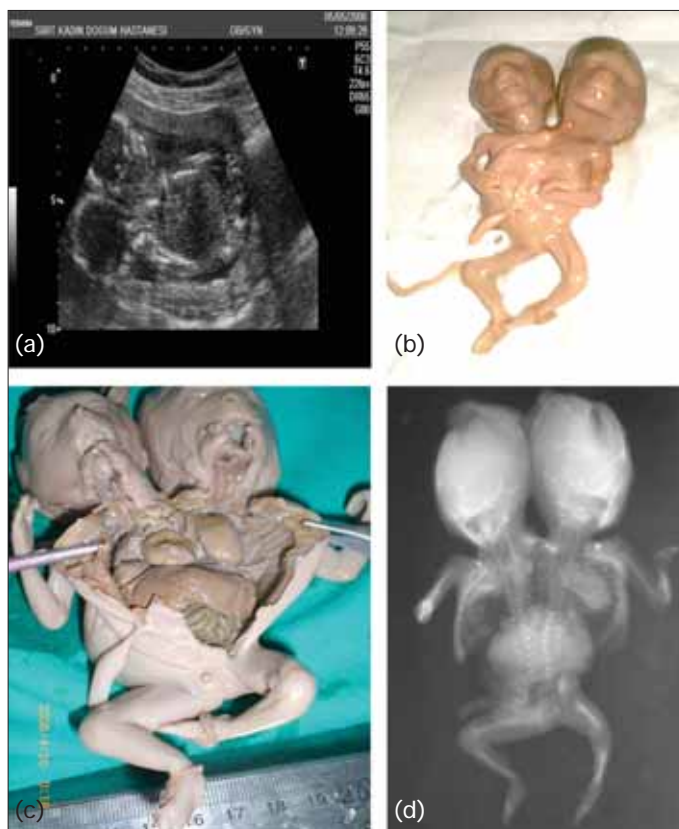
(a) Two-dimensional ultrasound scan of conjoined twins at 14-15 weeks of gestation. (b) Post-mortal image of the fetus anteriorly demonstrating two heads, two hands, and two lower limbs. (c) At autopsy, there were two separate structurally normal hearts. There were two larynxes and four lungs. The diaphragm is common and separated a single abdominal cavity. (d) A plain X-ray film showed two vertebral columns joining at the common pelvis and two separate chest cavities
